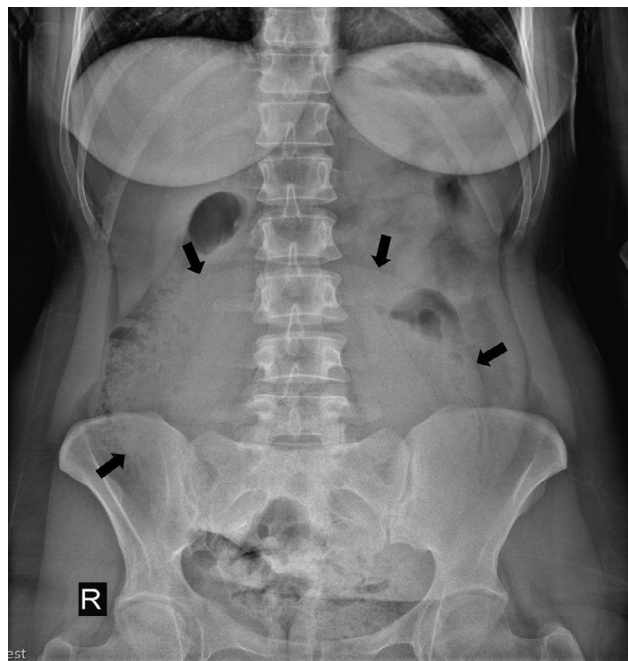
Abdominal radiograph shows a barely perceptible, centrally located soft tissue mass.
